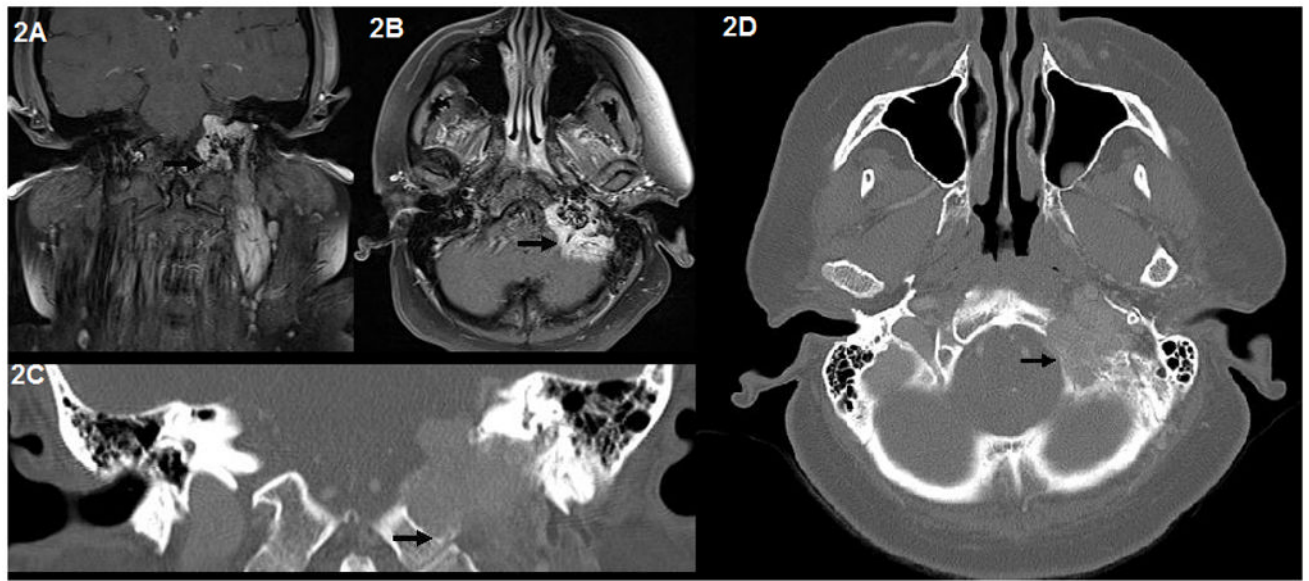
Coronal (2A) and Axial (2B) T1-weighted MRI sequences and HRCT images (2C and 2D) demonstrating an erosive left-sided jugular foramen lesion (arrows). Physical exam at the time of presentation revealed an ipsilateral true vocal fold paralysis, indicating involvement of cranial nerve X.
